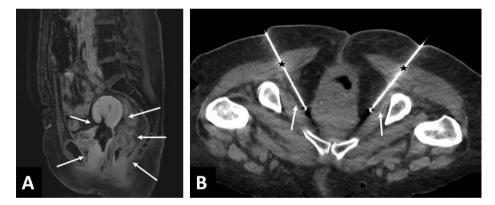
48-year-old woman with intractable pain related to a cervical mass and rectovaginal fistula. A. Fat-suppressed T1-weighted MR image in the sagittal plane obtained after intravenous administration of a gadolinium chelate shows cervical mass and rectovaginal fistula (arrows). B. Intraprocedural CT image obtained in the axial plane during palliative bilateral pudendal nerve cryoablation demonstrates cryoablation probes (stars) targeting the pudendal canal (arrows).
